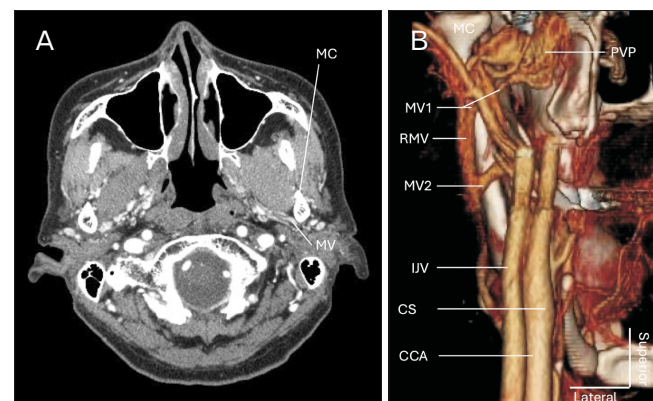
Contrast-enhanced computed tomographic images of the MV. (A) Axial image shows the relationship of the MC and MV. Posterior view of the three-dimensional reconstructed (B) computed tomographic images presenting the venous flow from the PVP to the RMV through the MV1. An additional MV2 drains into the RMV. MC, mandibular condyle; PVP, pterygoid venous plexus; MV, maxillary vein; RMV, retromandibular vein; IJV, internal jugular vein; CS, carotid sinus; CCA, common carotid artery.
